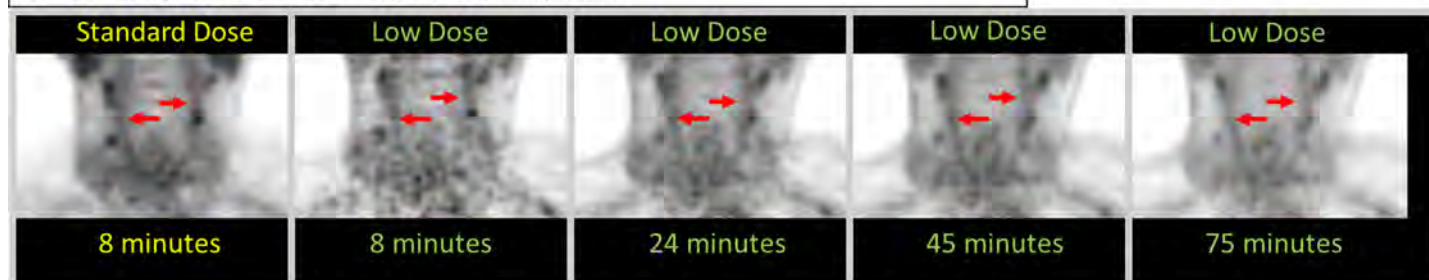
Representative coronal PET images in the same subject using the clinical standard dose of 18F-FDG acquired for 8 minutes compared to low dose images acquired for 8, 25, 45 and 75 minutes. Red arrows indicate the carotids.
